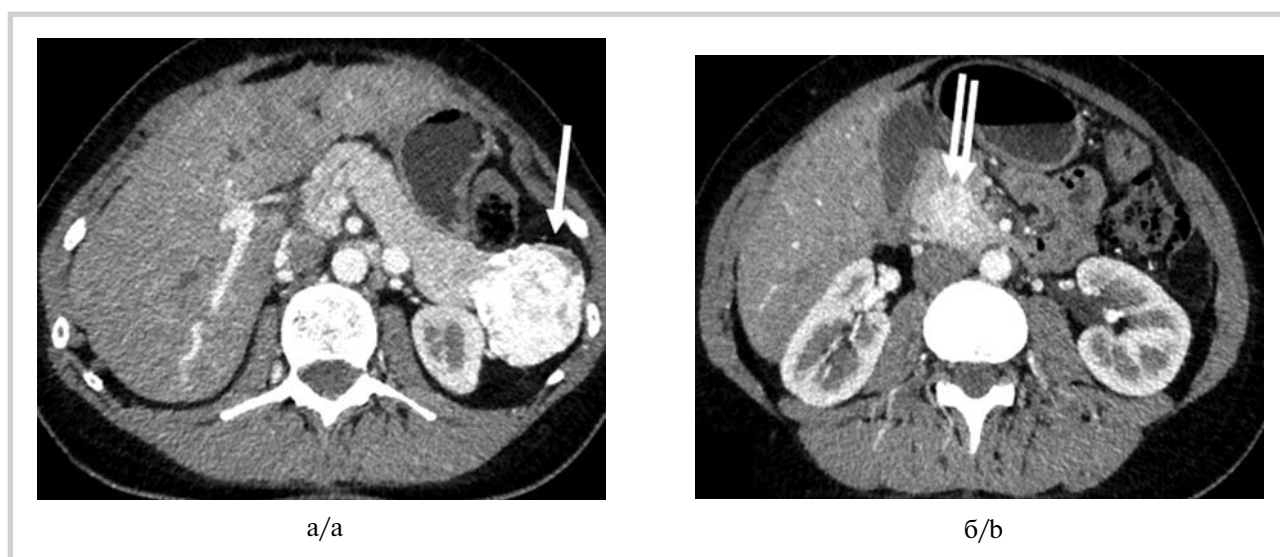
CT-scan, arterial phase, axial plane. A. NET (Grade 2) of the pancreatic tail 40×50 mm. B. NET (Grade 2) of the pancreatic head 17×21 mm.
